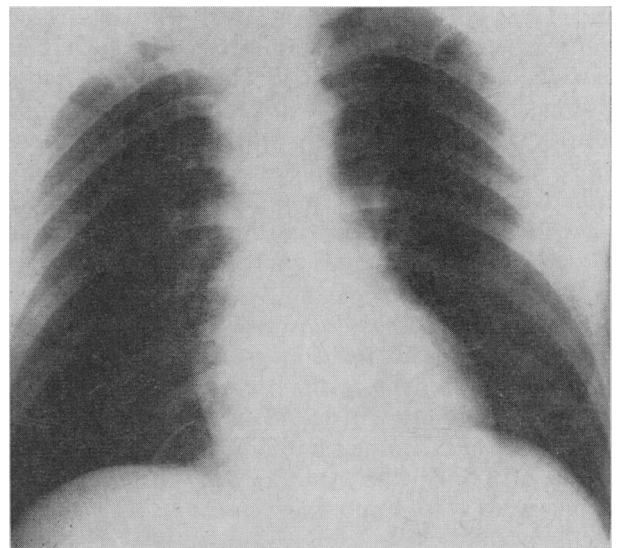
Chest radiograph of donor one day before he died. The lungs are large in size and there is no evidence of disease present.
